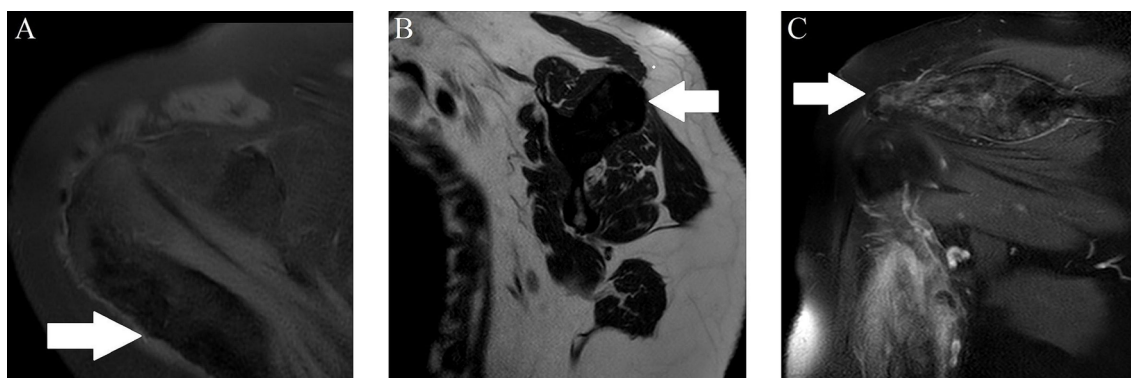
T1 SPIR MRI in axial section in A; T2-weighted MRI in sagittal section in B; Postcontrast T1 SPIR MRI coronal section in C revealing a heterogeneous and expansile bone lesion in the acromion (white arrows) with contrast enhancement.
